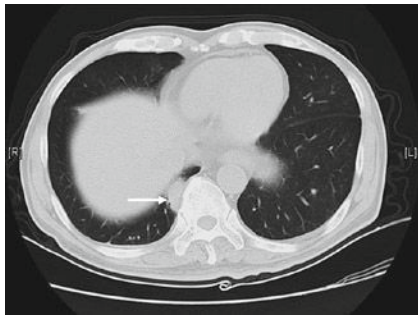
Computed tomography showed sub-segmental consolidation (arrow) in the posterior basal segment of the right lower lobe with homogeneous enhancement
